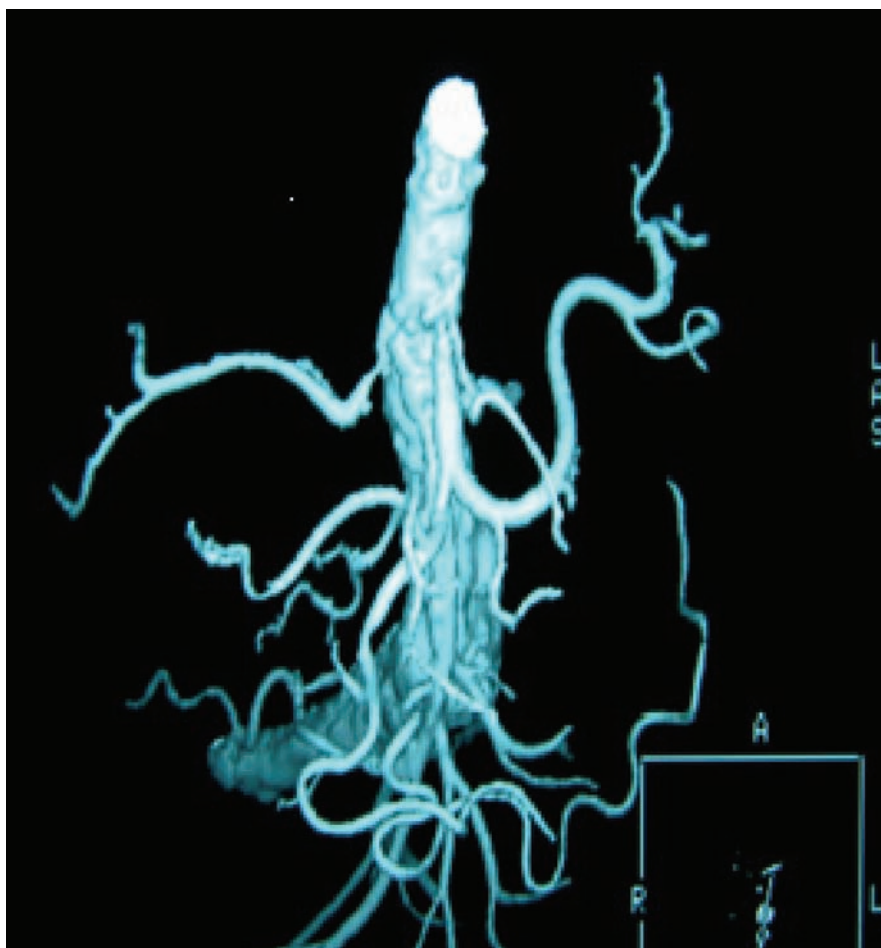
Reconstructed computed tomography image showing significant right renal artery stenosis (reproduced courtesy of Dr Alistair Cowie, Radiology Department, Salford Royal Hospital).
